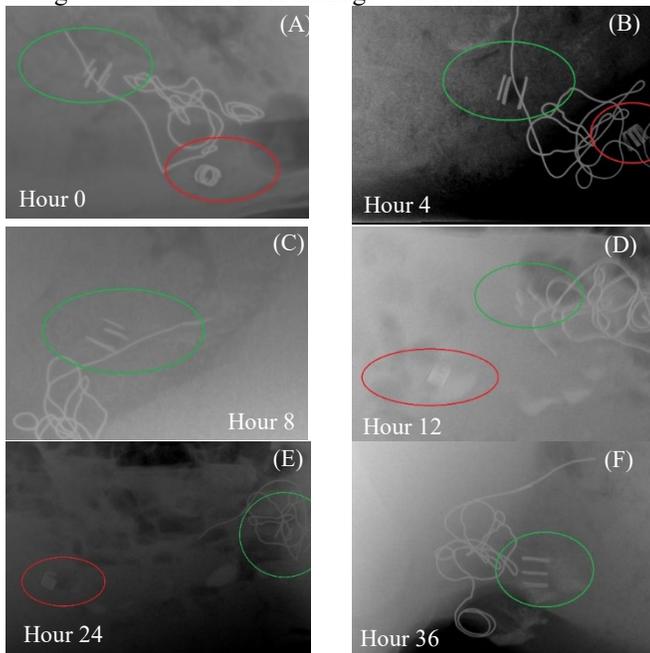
X-ray of the retention duration experiment. Green marks indicate the soft stent while the red marks indicate the control capsule. The control capsule moved to the large intestine within 12 hrs. after the surgery while the soft stent stayed for 36 hrs.
